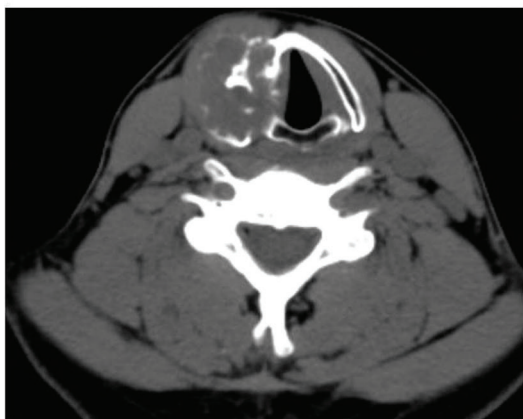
Preoperative CT scan showing a round shaped, calcified neoplasia of the right ala of the thyroid cartilage.
